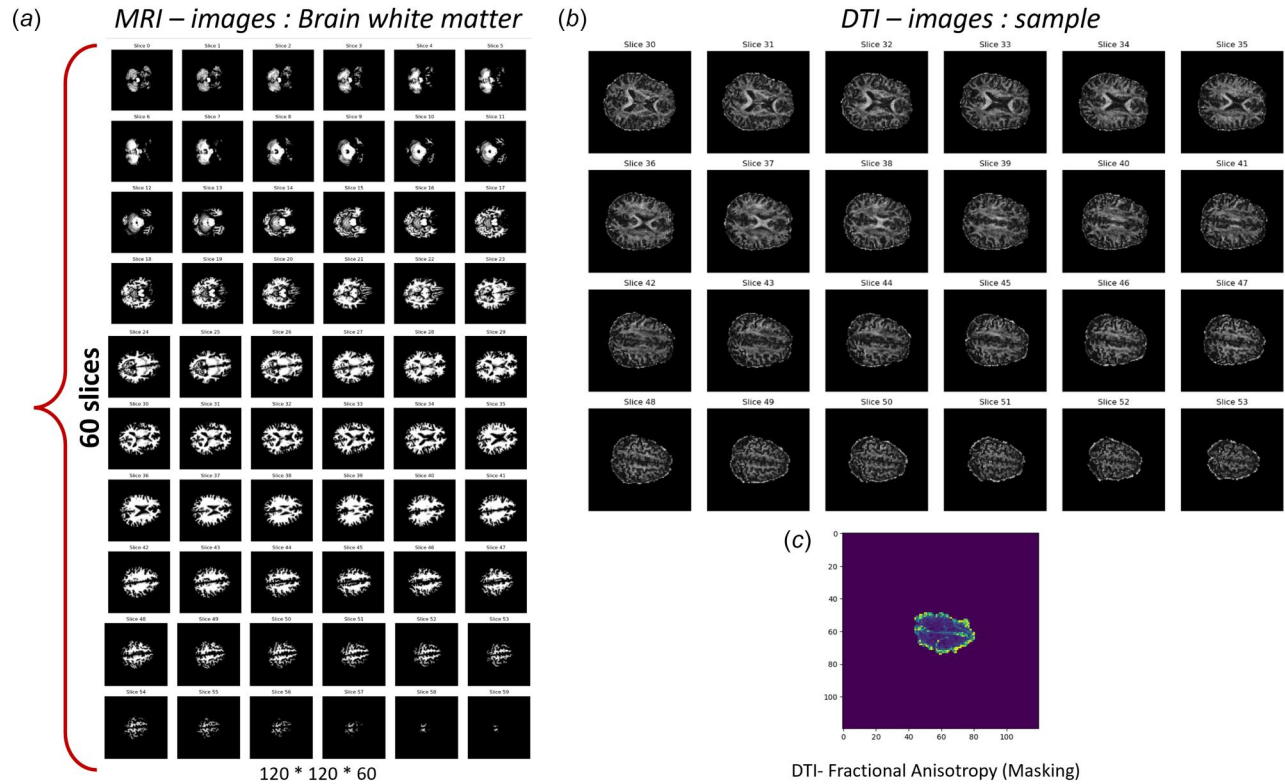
(a) Representative figure of MRI images from one of the patient subjects chosen for this study. 60 slices of 120 × 120 resolution. The functional MRI files are stored in the Nifti format, later processed in Python libraries (NiBabel). (b) DTI sample images, useful to understand integrity and connectivity in BWM, but not suitable for VF analysis since it does not provide anatomical details as MRI. (c) Masked images for FA measurement in DTI. All three images are for the same test subject (coded as MMMAB-0005, age 58 years). Refer Anderson et al. for more details on dataset [14].
